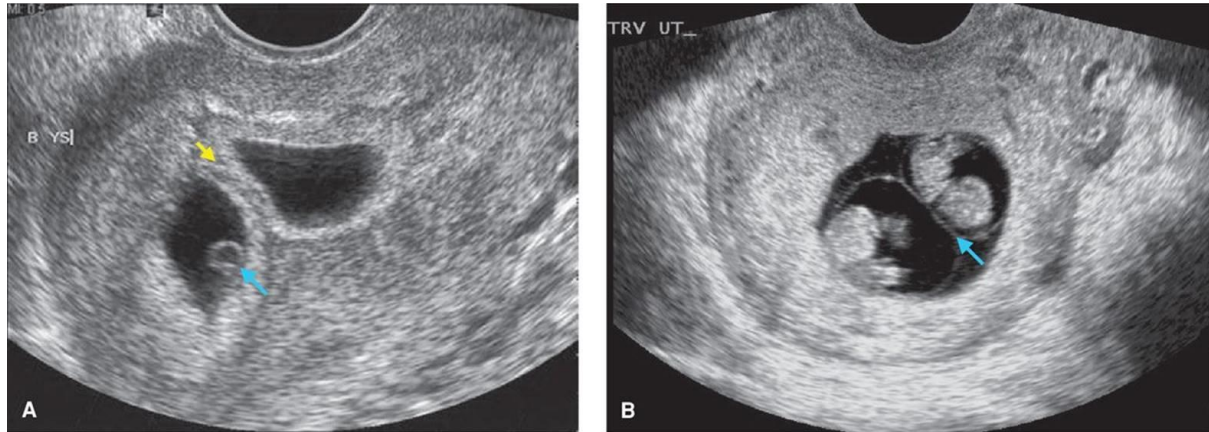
Sonograms of first-trimester twins.
